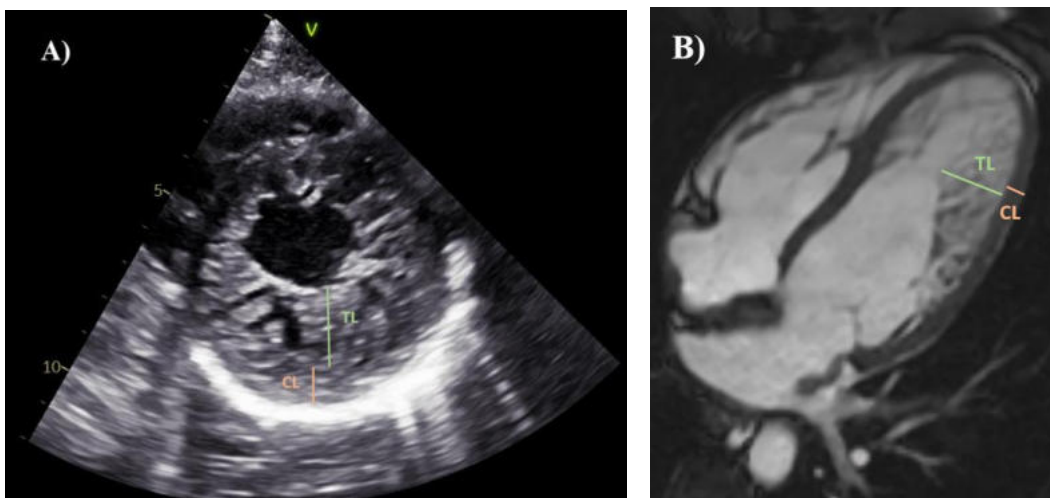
Imaging diagnostic criteria of left ventricular noncompaction. The echocardiographic image (A) describes the Jenni criteria on a parasternal short-axis end-systolic frame. The CMR image (B) represents the Petersen criteria on a four-chamber long-axis end-diastolic scan. CL = compact layer (red line), TL = trabeculated layer (green line), CMR = cardiac magnetic resonance imaging. Images belong to the Semmelweis University, Heart and Vascular Center.
